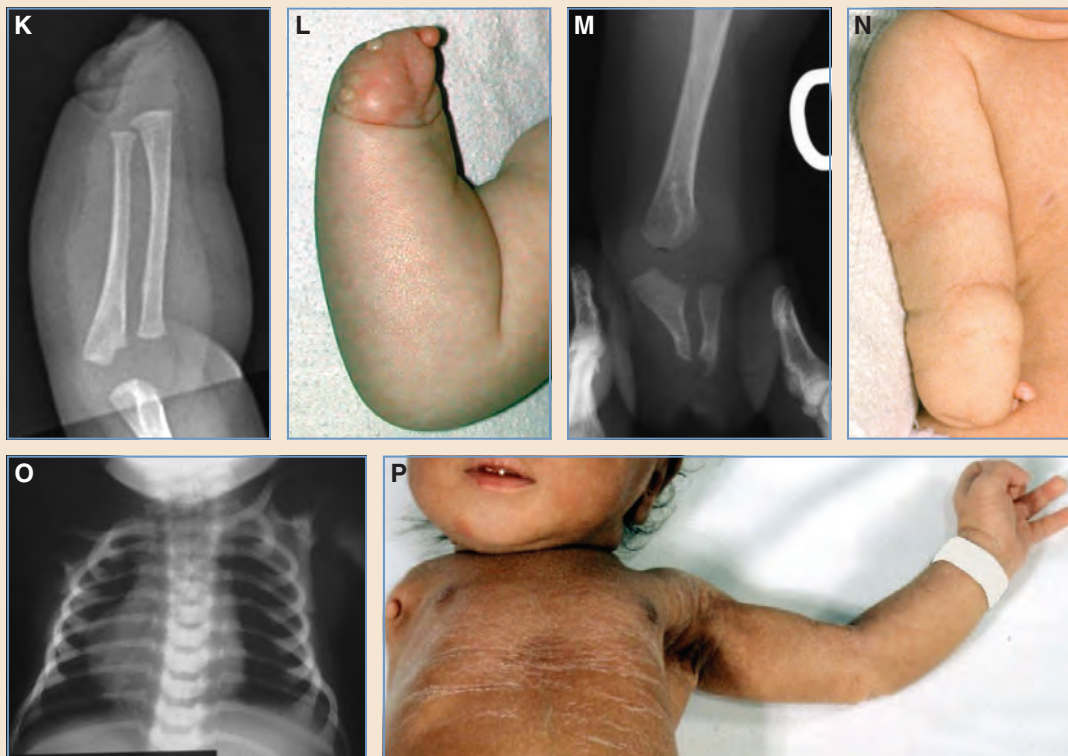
cont'd K and L, Anteroposterior radiograph and clinical photograph of acarpia symbrachydactyly (*peromelia*) of the right forearm and hand. None of the carpal bones are visible, because they have not yet ossified. M and N, Anteroposterior radiograph and clinical photograph of forearm amputation symbrachydactyly (*peromelia*) of the right upper limb. O, Anteroposterior radiograph with complete absence of the upper limb and clavicle. P, Complete absence of the right upper limb with a vestigial nubbin at the shoulder and a normal left upper limb. NOTE: Although this form is not part of the original Yamauchi and Tanabu classification system, it is hereby suggested that it be included and has been added for completeness.
